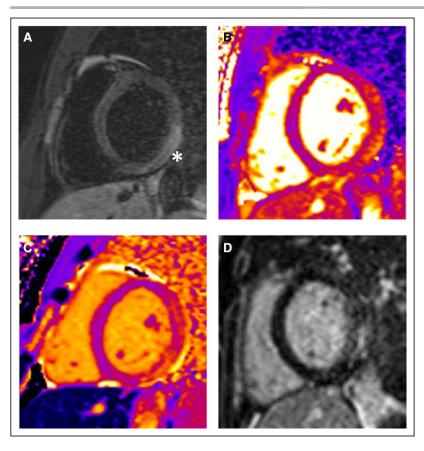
Tissue characterization with cardiac magnetic resonance imaging in myocarditis.
